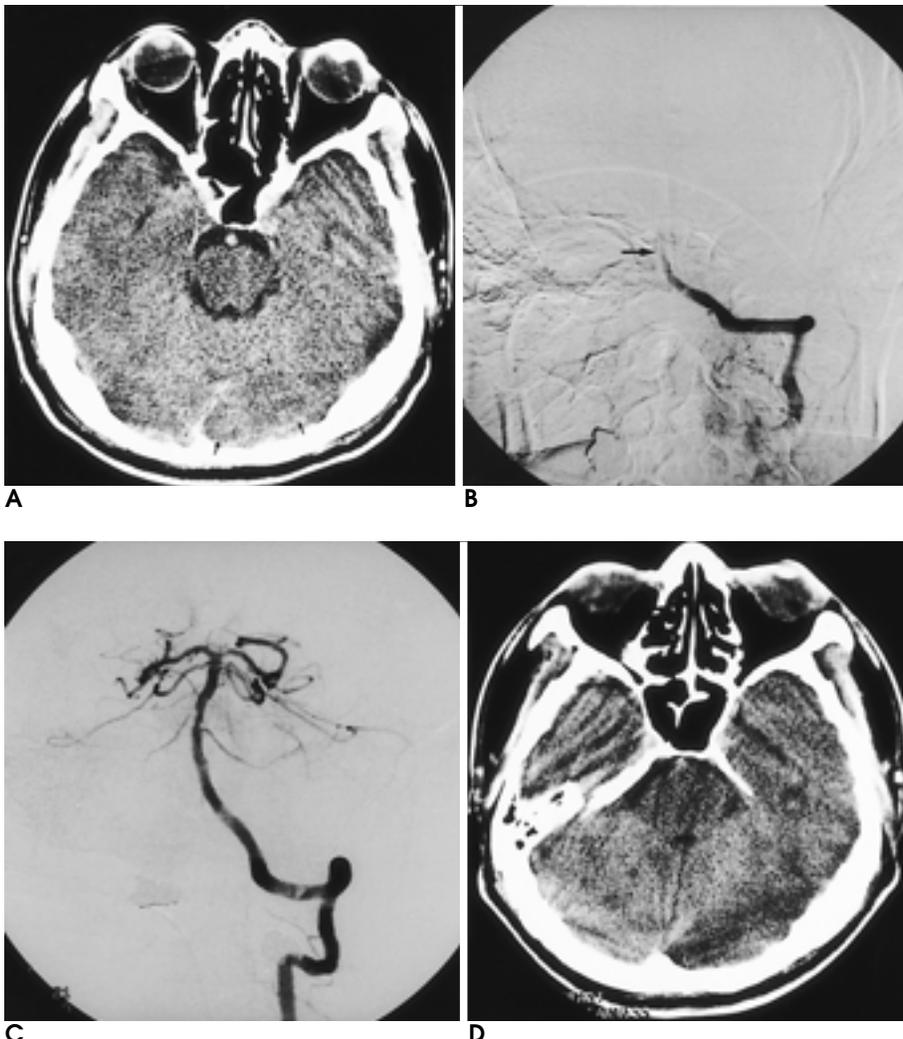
A 50-year-old man with right-sided weakness and deeply drowsy state received thrombolytic therapy 4 hours after onset of symptoms. Pretreatment CT (A) shows suspicious hypodensity (arrows) in the left occipital lobe. Frontal projection on the vertebral angiogram (B) shows complete occlusion of the proximal basilar artery (arrow). After infusion of 600,000 IU of urokinase, complete recanalization is obtained (C). CT 24 hours after thrombolysis (D) shows acute infarct in the brainstem and the territory of both posterior cerebral arteries. The patient died of brainstem infarct 4 days after thrombolytic therapy.
